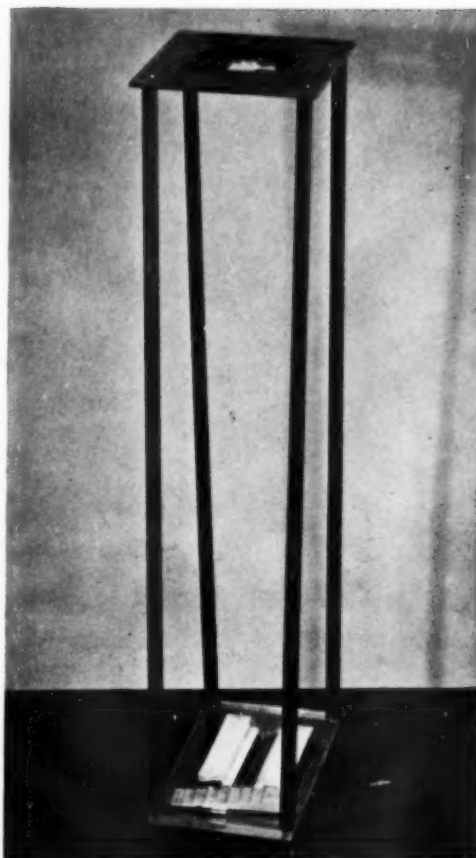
Apparatus to aid in exposing roentgenograms for estimation of the mineral content of bone. The top plate fits snugly into the cone slot of the roentgenographic tube. The lead diaphragm confines the x-rays to the plexiglas plate below. The protrusion to the right in the diaphragm allows the passage of rays so as to include the knee in the roentgenogram. Below is a plexiglas plate on which are mounted two beef-bone ladders and an aluminum ladder. The aluminum ladder will not be used routinely. The length of the device is made to correlate with the proper distance for the Potter-Bucky diaphragm.
